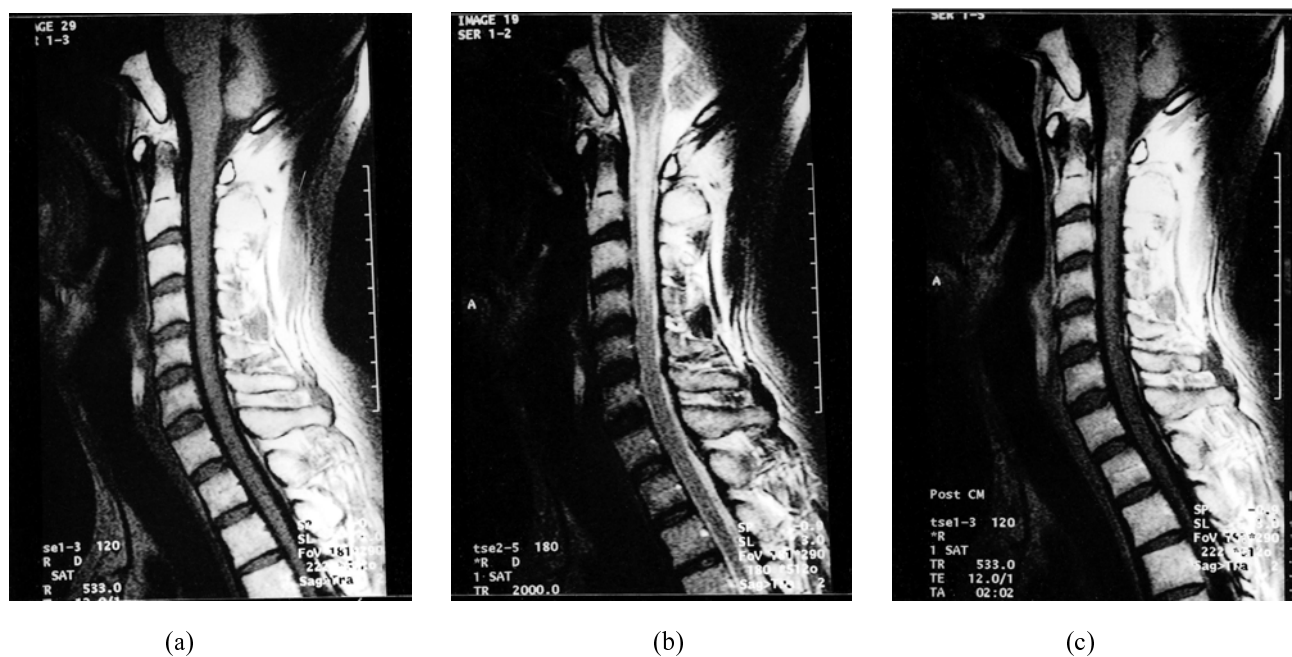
C-spine MRI in August 1999. a: Cord enlargement at the level of C1-3 was showed on sagittal T1WI. b: Bright signal intensity was showed at the same level on T2WI indicating cord edema. c: Intramedullary contrast-enhancement was showed on post-contrast enhanced T1WI.
